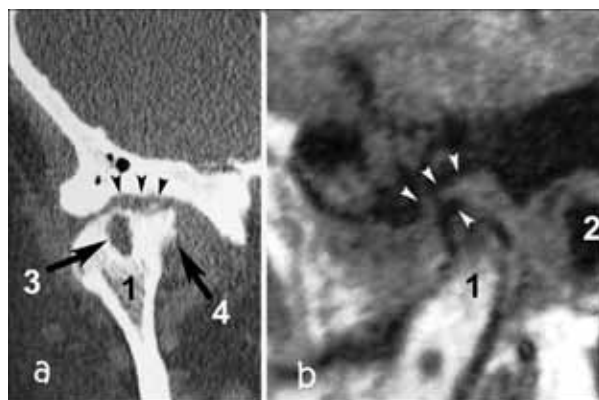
Osteoarthritic TMJ in coronar plane by computerized tomography (a) and sagittal plane by MRI (b): 1 – condyle, 2 – external auditory meatus, 3 – osteoarthritic cyst, 4 – osteophyte formation, arrows – sclerosis of the articular eminence and condylar surfaces.
